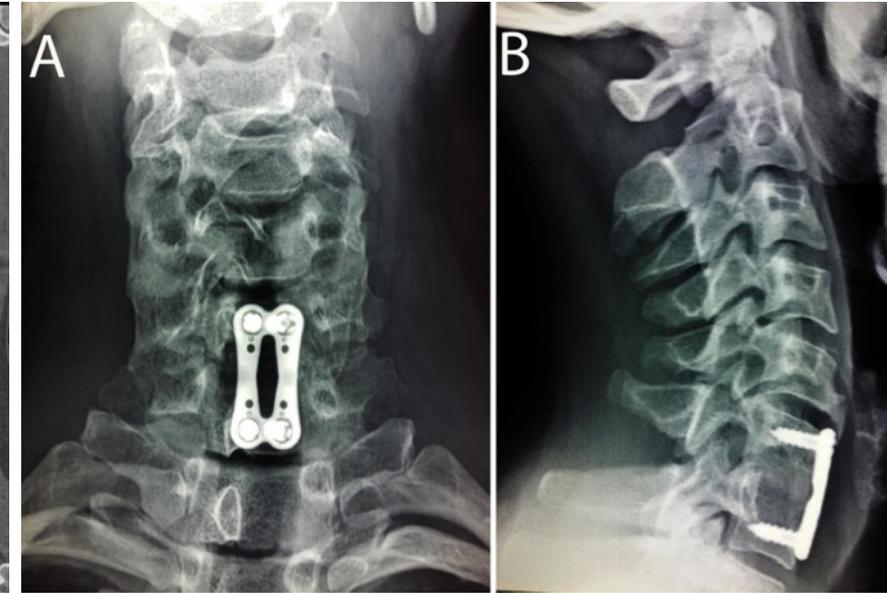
Ben's X-ray images: 4.5 years after injury (16/5/2017)
